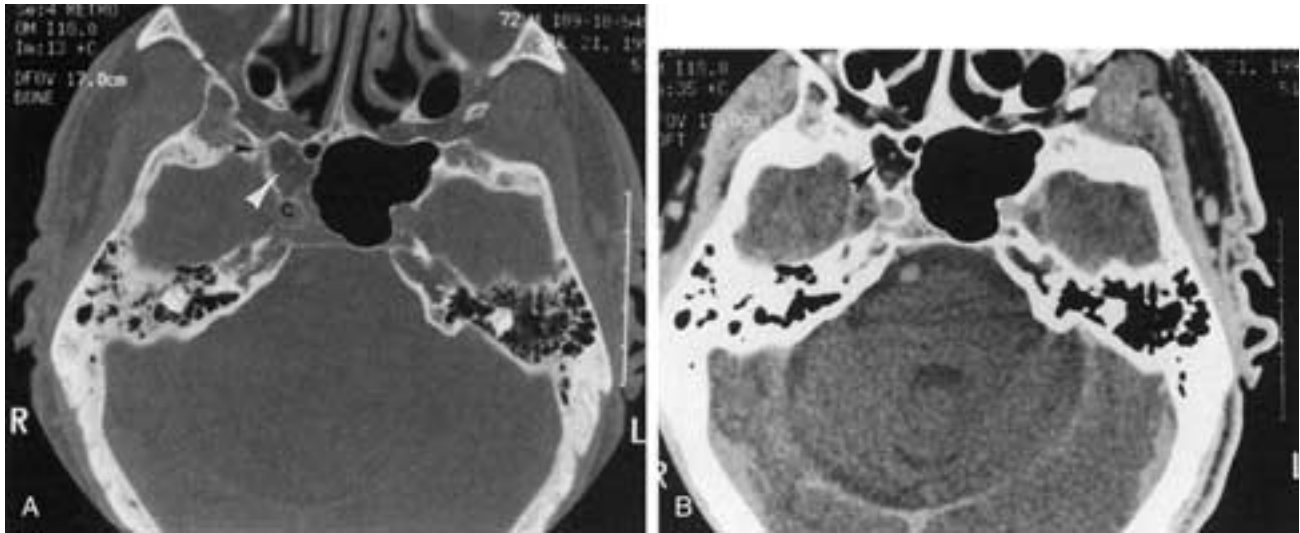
A, Normal nonpneumatized CT bone algorithm. An area (*white arrowhead*) in the right sphenoid initially can be confused with an obstructed sinus. However, on careful inspection, there appear to be trabeculae within the area. The foramen rotundum (*black arrowhead*) is seen just lateral to the area in question. B, On the soft-tissue algorithm at the same level, the area of concern shows a fatty density (*arrowhead*), indicating that this indeed represents normal fatty marrow.
